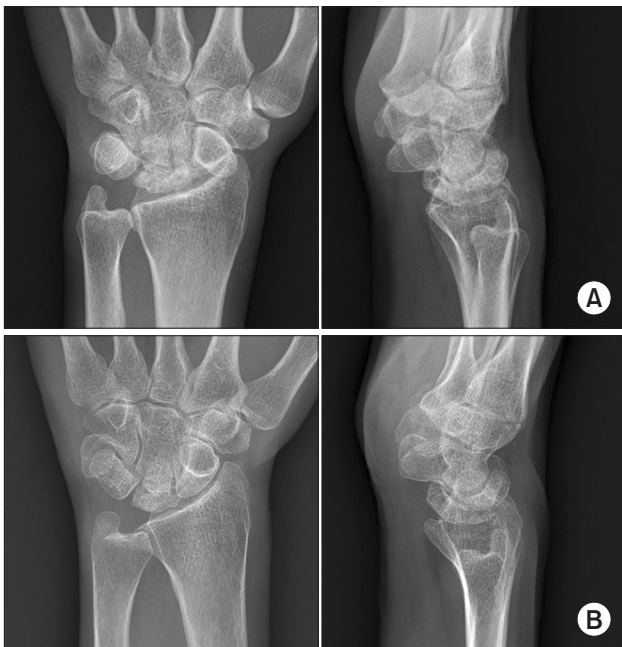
A 50-year-old woman underwent carpal tunnel release and her concomitantly found Kienböck's disease (Lichtman stage 3B) was closely observed for its clinical and radiographic progression. (A) Initial radiographs showed collapse of the lunate with evident sclerotic change. (B) Radiographs taken 10.7 years after the diagnosis showed an apparent increase in the height of the lunate. Note the trabecular pattern inside the lunate, which became similar to that of other carpal bones. Intermittent pain existed, but the patient was satisfied with not having undergone surgery for Kienböck's disease.
